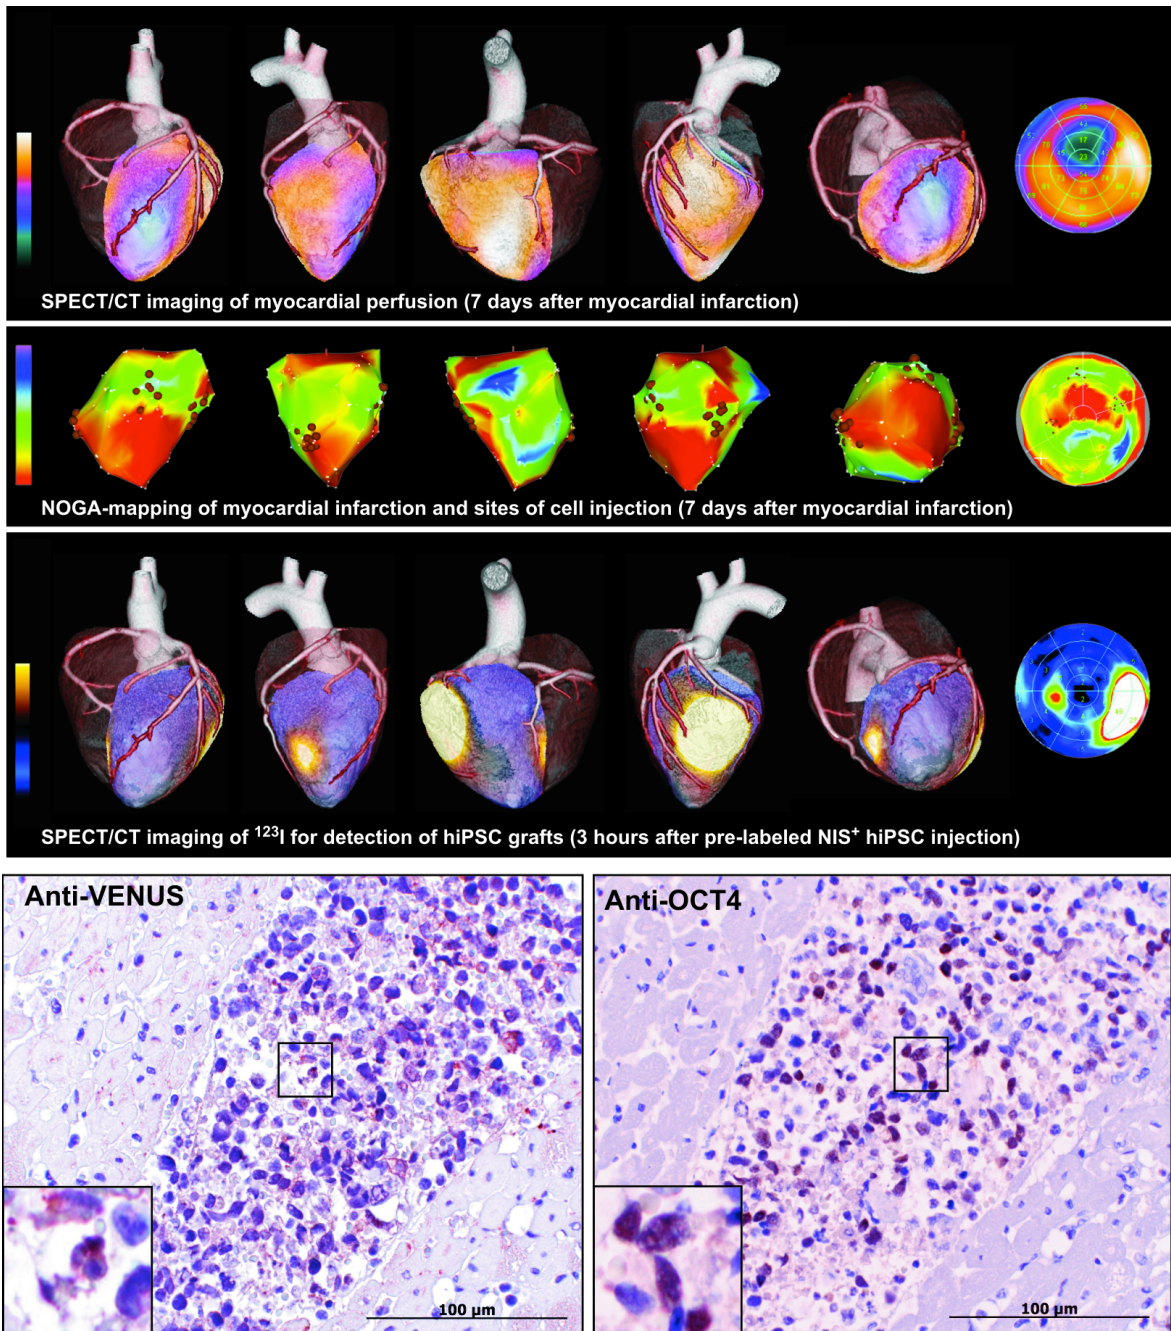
In vivo* Hybrid-SPECT-CT Imaging zur Detektion des myokardialen Perfusionsdefektes und der transplantierten NIS^+ -hiPSCs
